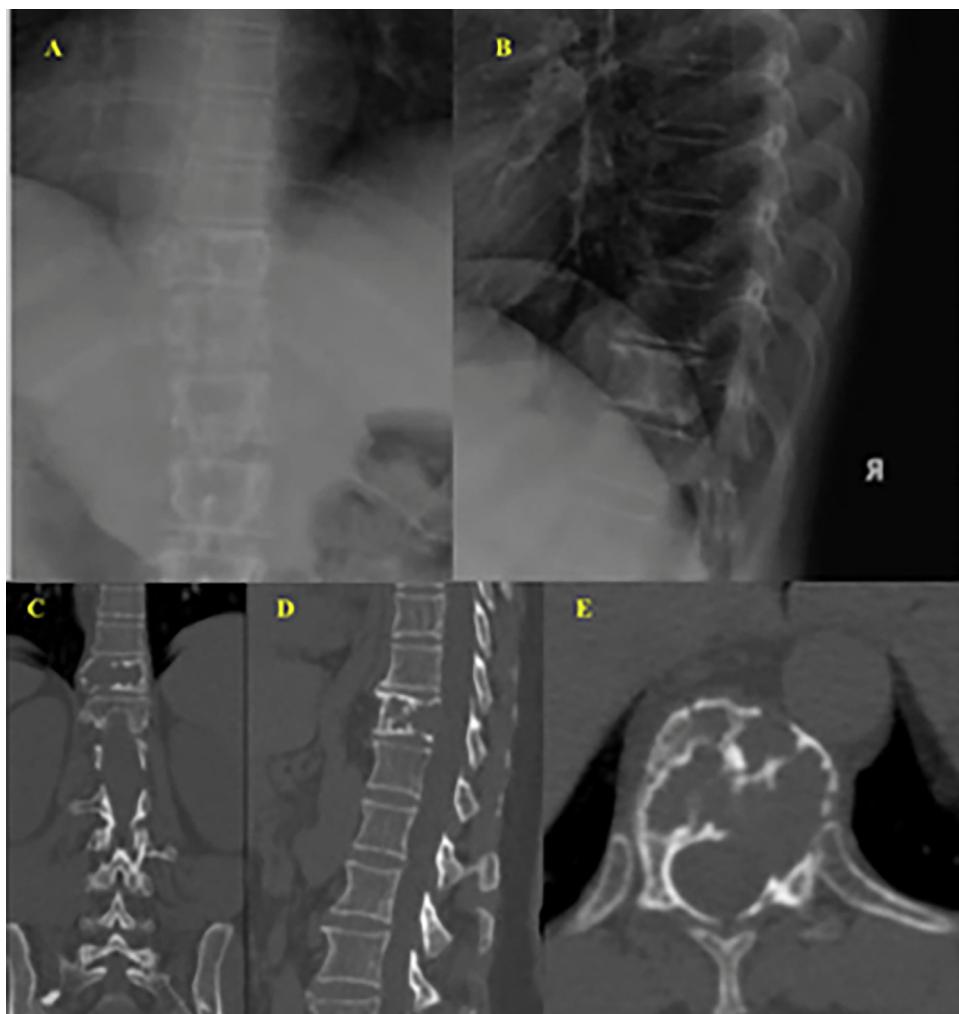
A,B) Anteroposterior and lateral radiograph showed a discrete loss of height and asymmetry of the T11 vertebral body and as well as cortical expansion, effacement of the left pedicle and sclerosis. C-D) CT showed an expanded lobular lytic lesion boundary, partial sclerotic borders of the T11 vertebral body and thinning with anterior cortical and posterior wall rupture.
